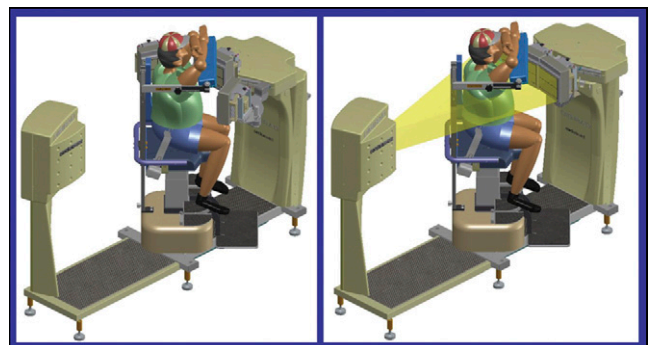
Digirad solid-state SPECT for upright myocardial perfusion imaging obtains images in (left) emission mode and (right) transmission mode for attenuation correction.
